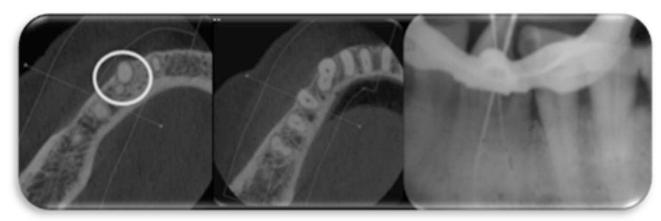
Working length & CBCT.
